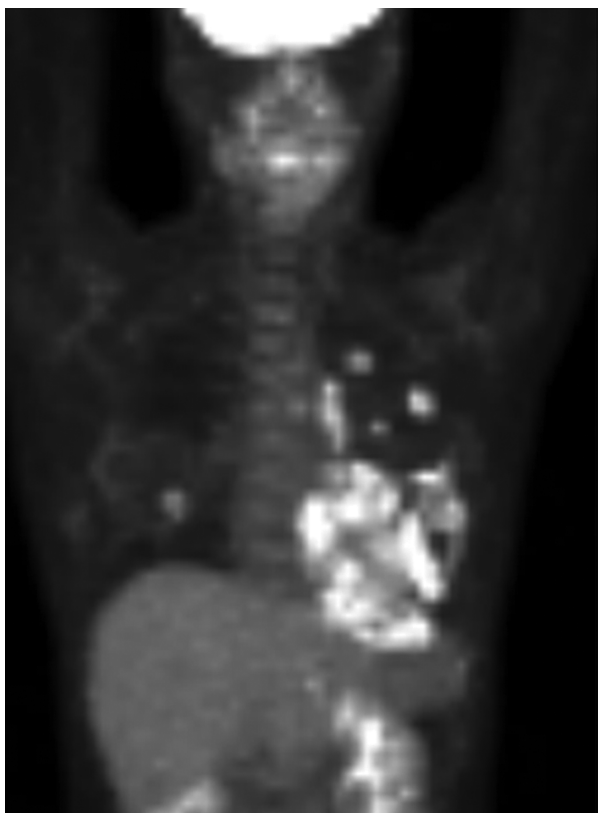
The preoperative fluorodeoxyglucose-positron emission tomography (FDG-PET) scan. The FDG-PET scan showed significant dissemination in the left pleural cavity.
